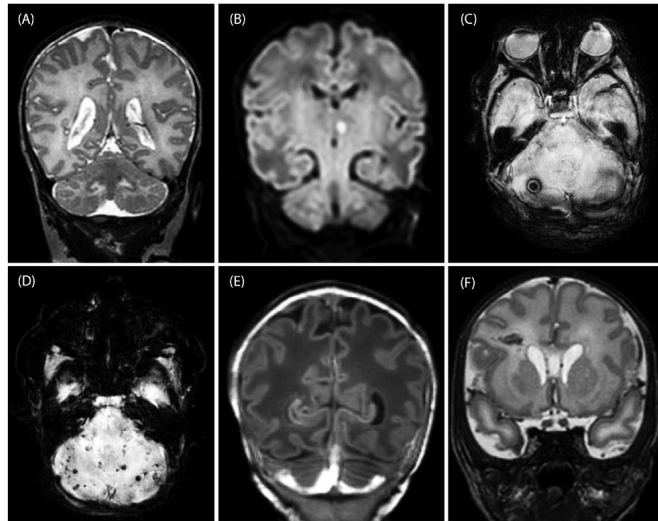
Brain injury visible on MRI in preterm infants. A, cT2, 12 days after gastroschisis repair:  $\geq 6$  punctate white matter lesions; B, cDWI, 6 days after jejunal atresia repair: thalamic infarction; C, SWI, 8 days after gastroschisis repair: cerebellar hemorrhage; D, SWI, 3 days after urethral valves repair: multiple cerebellar hemorrhages; E, cT1, 7 days after duodenal atresia: subdural hemorrhage; and F, cT2, 7 days after intestinal atresia repair: periventricular hemorrhagic infarction.
